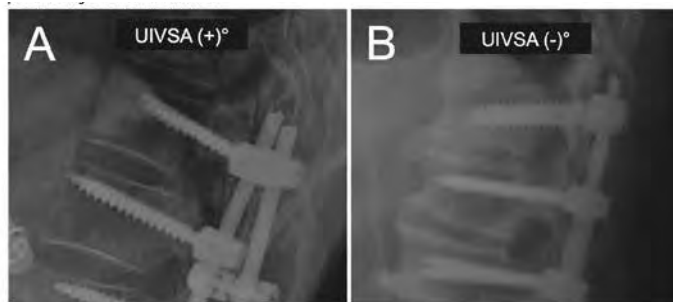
Sagittal Intraoperative Radiographs Demonstrating Positive (A) and Negative (B) UIVSA. Patients with UIVSA $\geq +3^\circ$ are at significantly greater odds of developing PJK and PJF.
